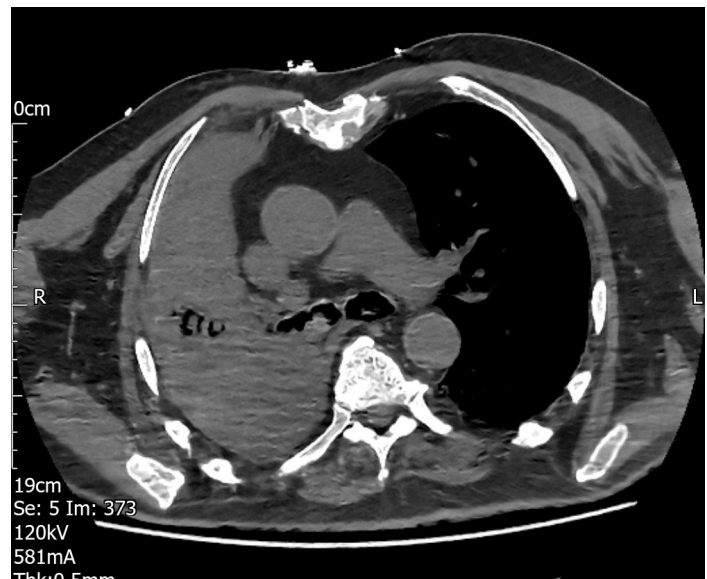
CT angio of chest (axial, sagittal)
